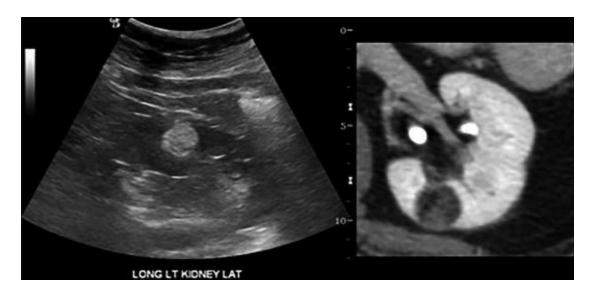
Ultrasound demonstrates a hyperechoic solid left interpolar renal lesion. Contrast-enhanced CT confirms intralesional fat consistent with an angiomyolipoma
